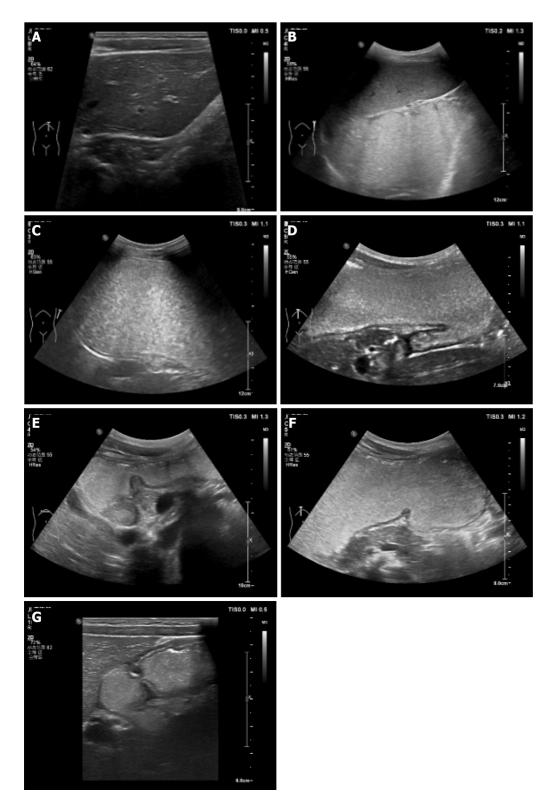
Contrast-enhanced ultrasound scanning. A: Section of cardia and lower esophagus; B: Section of gastric fundus; C: Section of the gastric body; D: Gastric angle section; E: Antrum section; F: Gastric coronal oblique section; G: Duodenal section.
